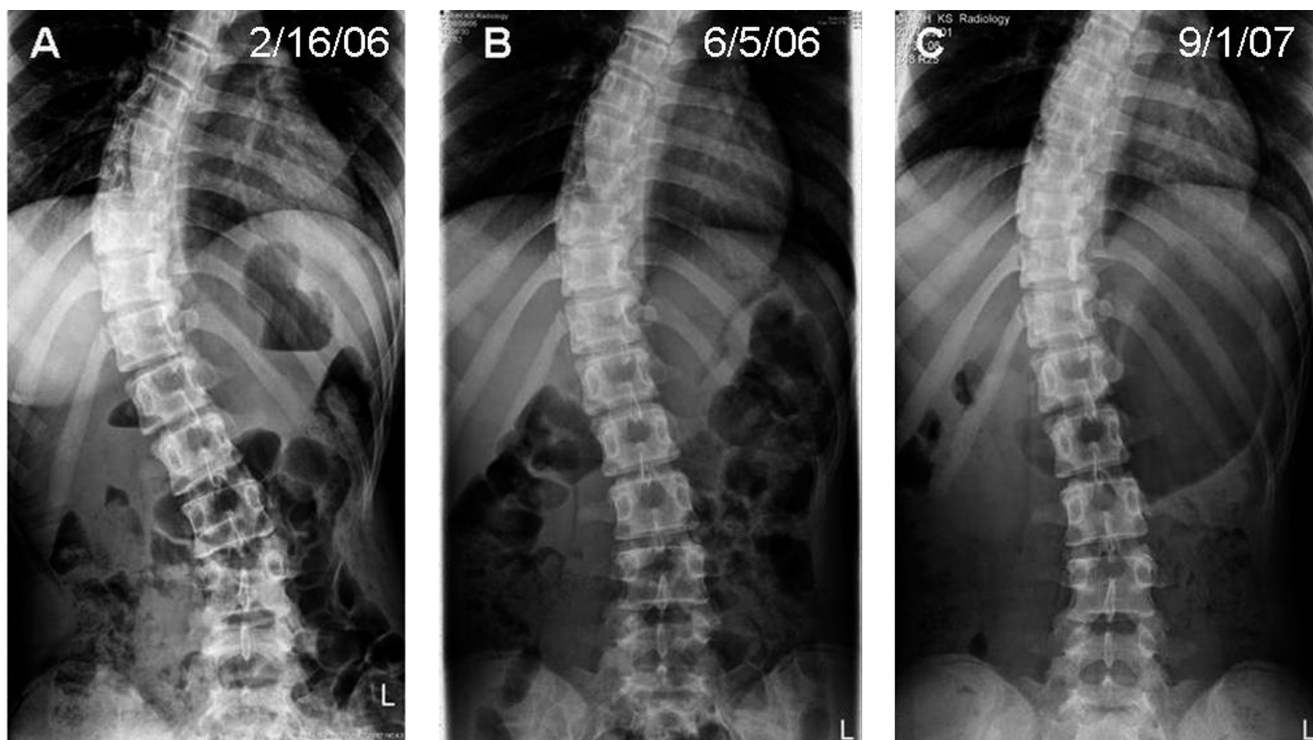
Thoracolumbar X-ray films (A–C) demonstrating decrease in scoliosis in a 15-year-old girl during 18 months following the addition of spinal manipulation to therapeutic regimen of bracing and rehabilitation. Part C also shows a significant decrease in feces and bowel gas, coinciding with improved bowel function.
